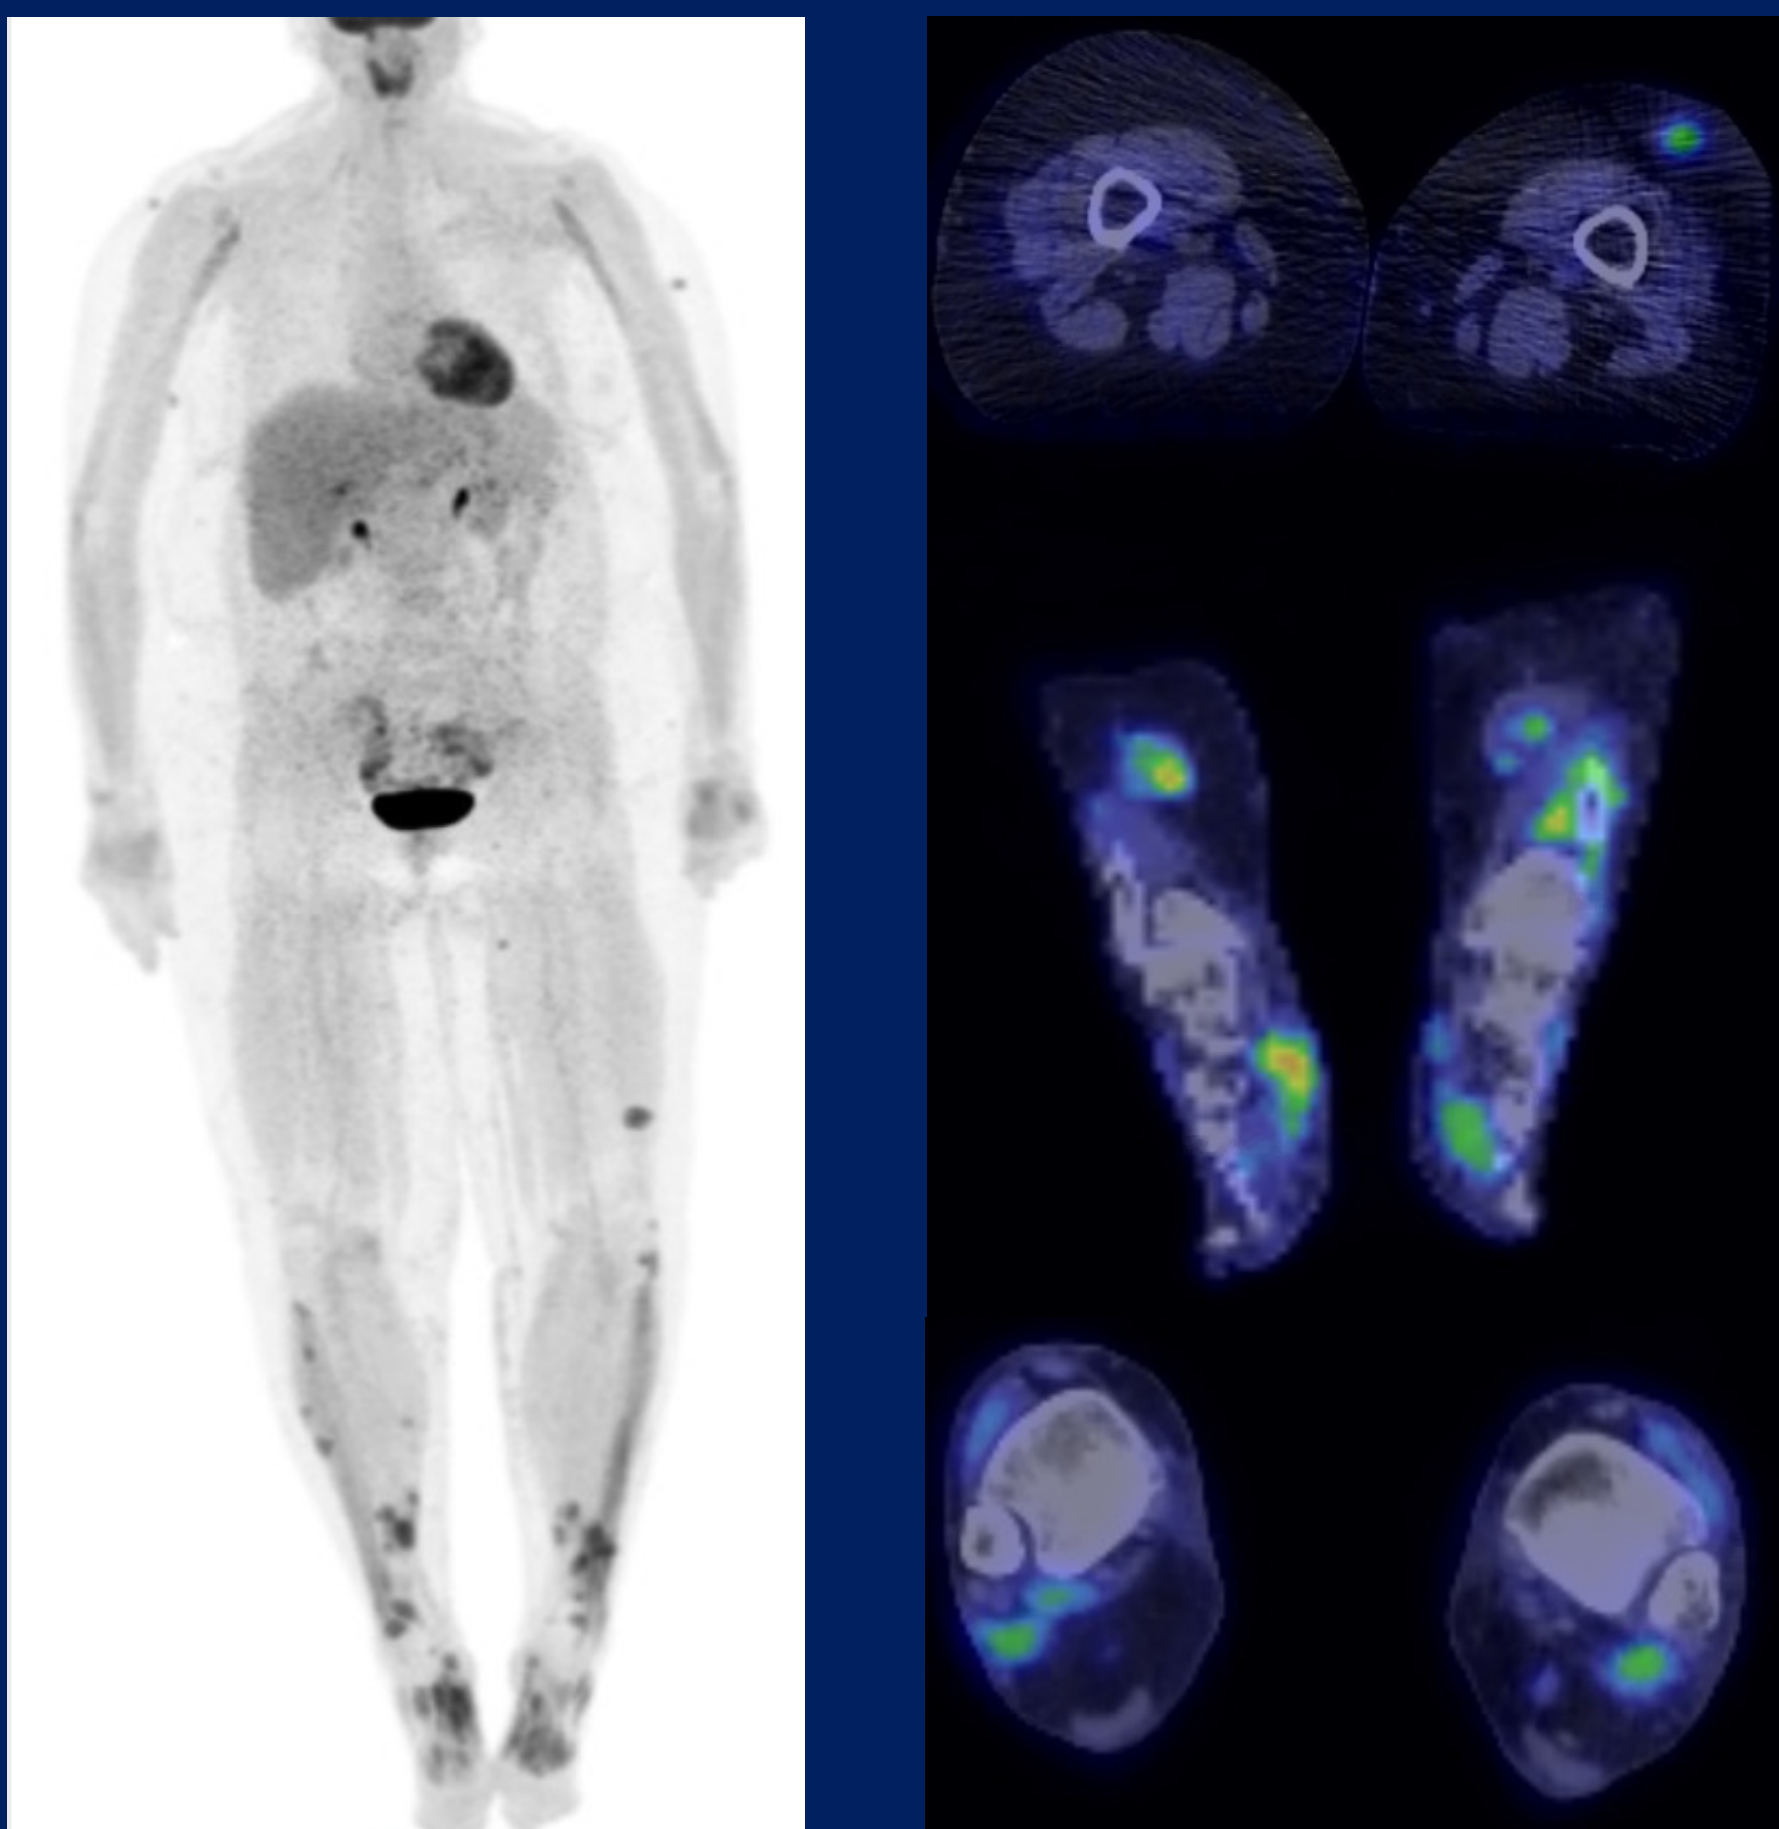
May 2020 whole body PET/CT showing metabolically active disease (left) with details of thighs, legs and ankle involvement (right).
